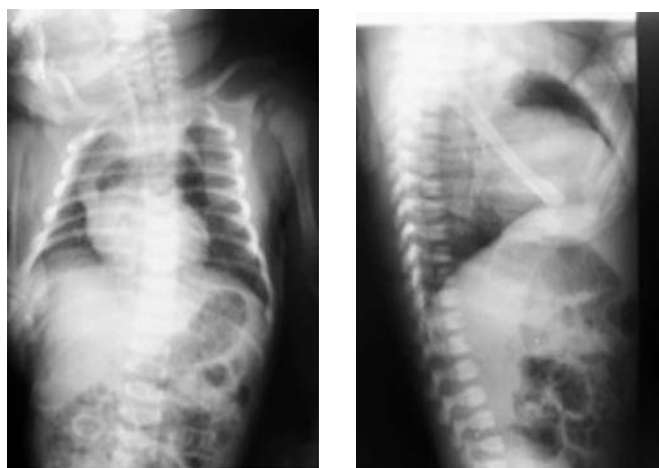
Posteroanterior (a) and lateral (b) chest radiographs.
